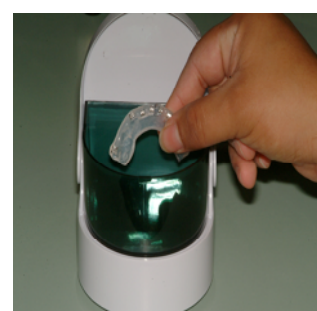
Cleansing of tray in ultrasonic solution.*
